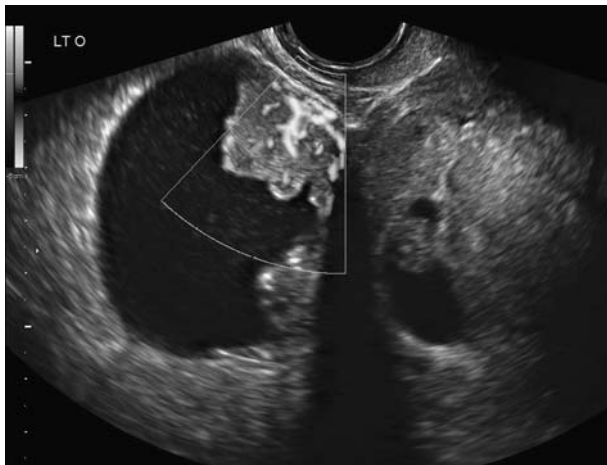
Malignancy. Ultrasound image of an endometrioid ovarian adenocarcinoma with papillary projections diagnosed during pregnancy. Image courtesy of Dr. Bryann Bromley.
